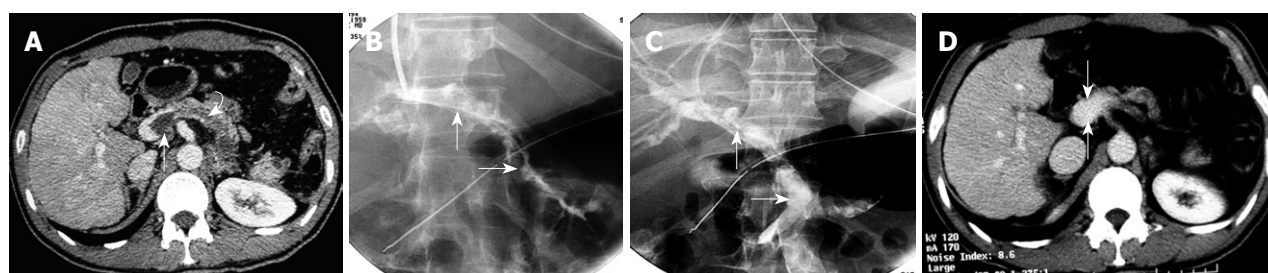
Case 4: A 42-year-old man with abdominal pain, diarrhea, and nausea for 2 wk. He had undergone splenectomy 4 wk previously. A: Selected axial image from admission contrast-enhanced CT demonstrates massive thrombus within the proximal of SMV (arrow) and the stump of the splenic vein (curved arrow); B: Pre-treatment direct venography via transjugular approach access to the portal vein showing extensive PV-SMV thrombosis (arrows), without collateral drainage; C: Immediate follow-up direct portal venography after catheter fragmentation and aspiration of the PV-SMV thrombosis, shows 75% reduction of thrombosis in the SMV and PV (arrow). The catheter infusion of thrombolytics was continued for 4 d and further improvement was confirmed by CT follow-up; D: Contrast-enhanced CT image at the same level as in Figure 4A obtained 5 d after completion of the interventional procedure shows a wide patent SMV (arrows).
